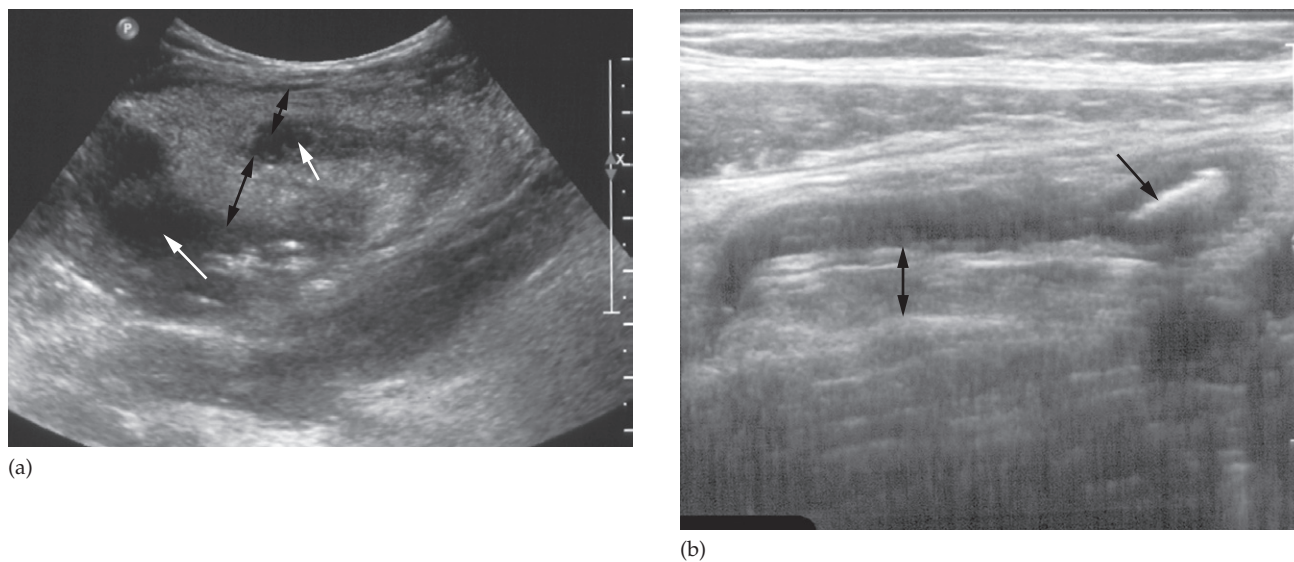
Appendicitis. (a) Longitudinal ultrasound scan demonstrating marked thickening of the wall of the appendix (double head arrows). Fluid is seen within the lumen and surrounding the appendix (white arrows). (b) An appendicolith is seen in the tip of the appendix in a different patient (black arrow). A double-headed arrow again indicates thickening of the appendix wall.
